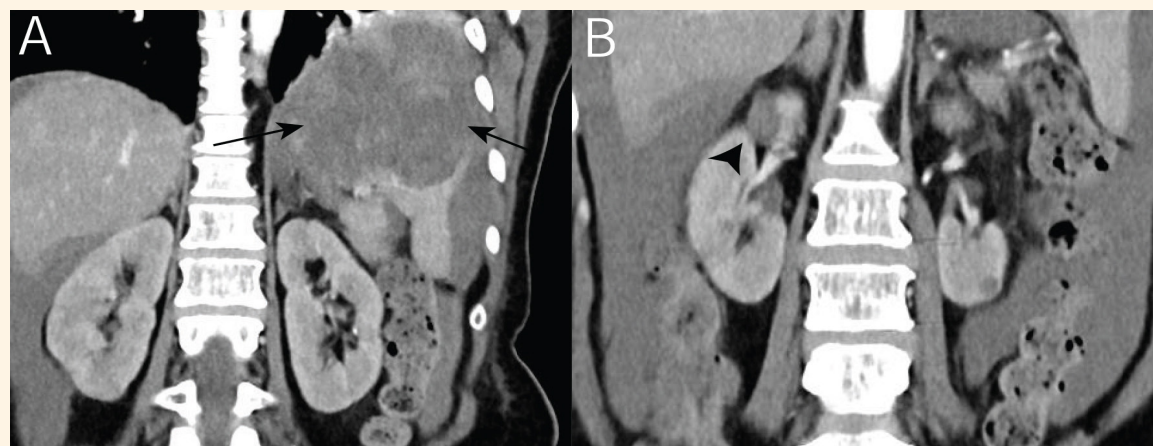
Contrast enhanced computed tomography (CT) performed after 25 days from initial CT because patient showed sudden drop of haemoglobin. Coronal reformat CT (A) revealing newly developed moderate hemoperitoneum with rapid increase in size of splenic haemorrhagic masses (black arrows) that are likely the cause of the retroperitoneal bleed. In addition, (B) the right renal mass has also progressed in size (arrowhead).
